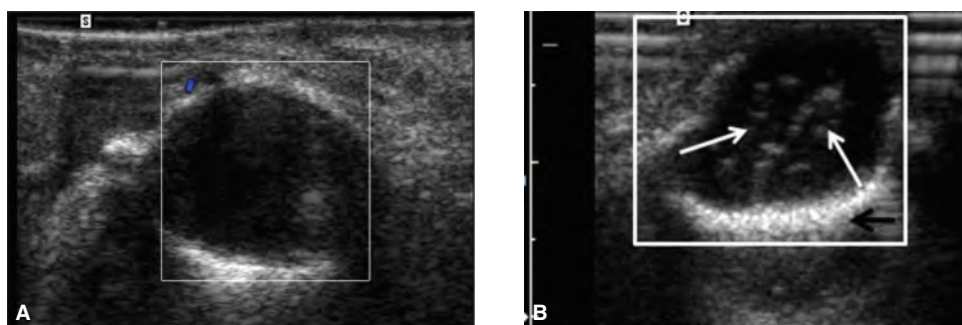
6 Ultrasound image of two cystic lesions. A. This cyst presents an “anechoic”/ “transonic” cavity (framed) with reinforced, hyperechoic, bone contours. B. This cyst presents a transonic cavity filled with fluids and containing inclusions (arrows), with reinforced bone contour (arrow head).
